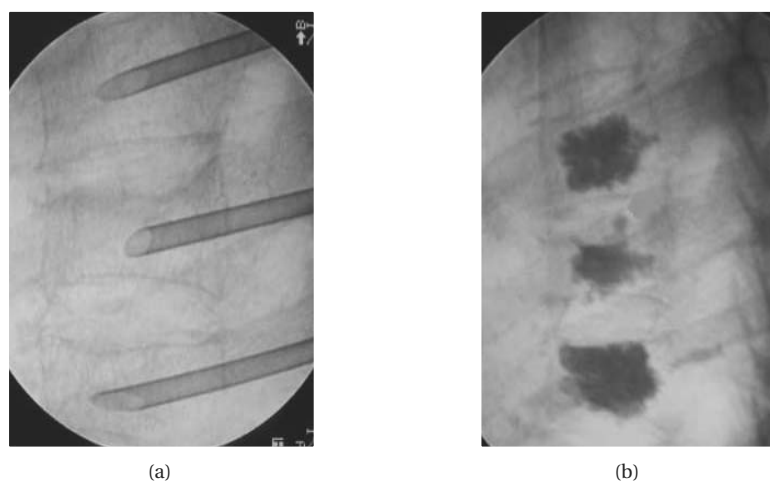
Left lateral fluoroscopic X-ray image of a three-level thoracic vertebroplasty: (a) after the needle insertions; (b) after the cement injection and the removal of the needles, from [Hide 2004].
